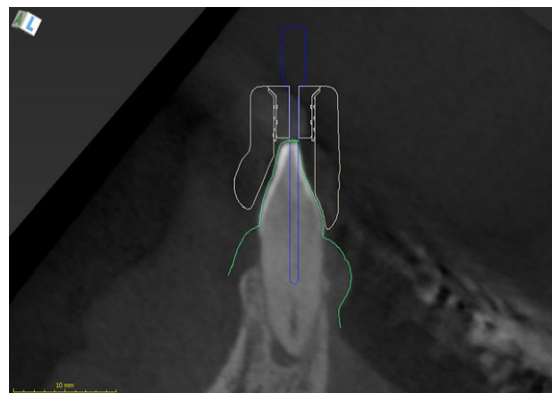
Virtual planning of minimally invasive access cavity. The virtual copy of the drill is placed in such a way that the tip touches the radiographically visible part of the calcified root canal.
